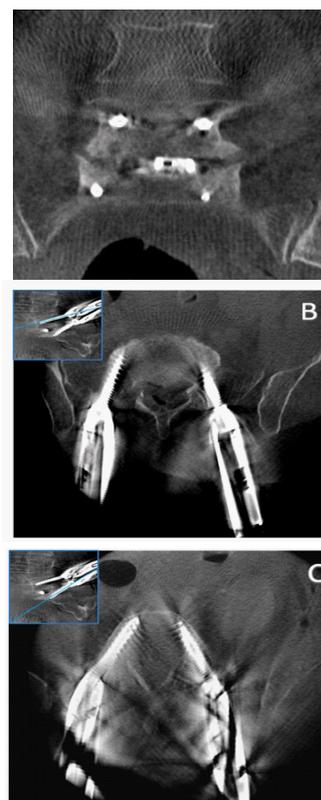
A coronal, B axial L5 and C axial S1 intraoperative CT scan acquisitions.
